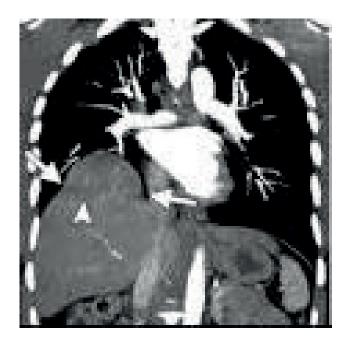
Hump sign of the diaphragmatic injury in CT scan (showed by arrows).
